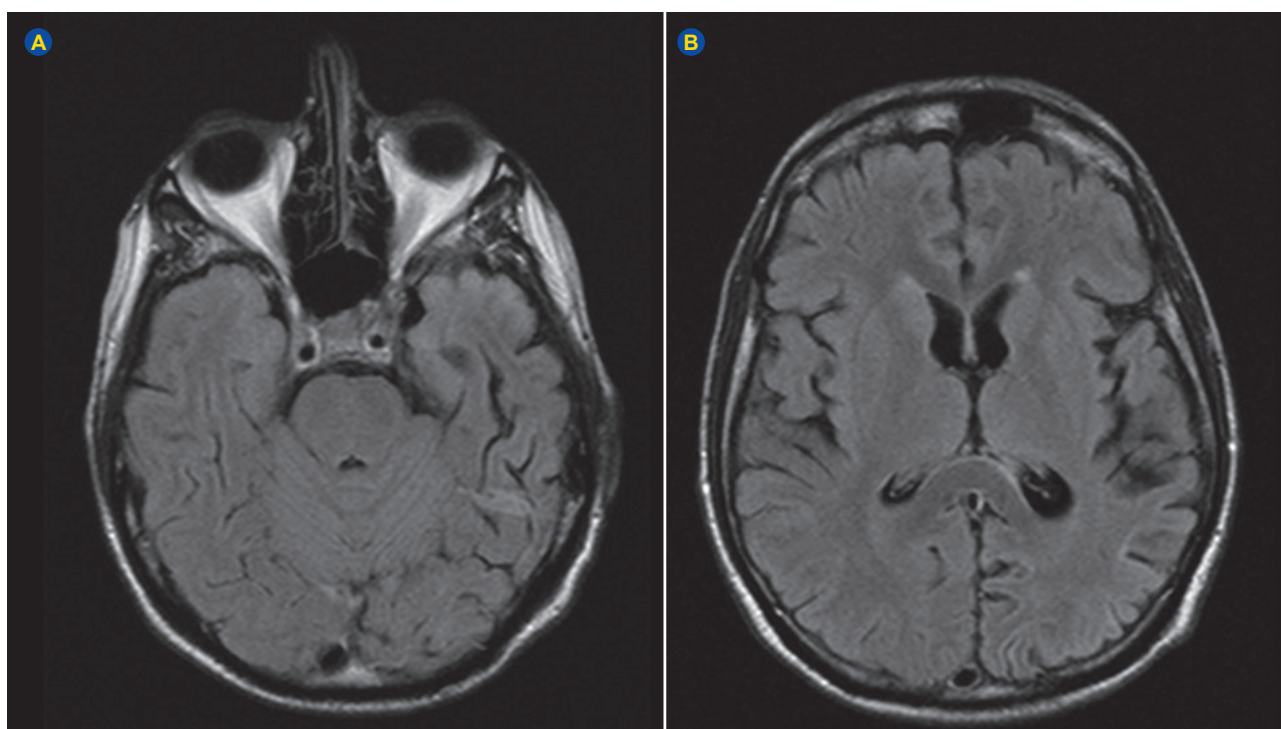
MRI in August 2019 showed reversal of imaging changes with increased peripheral cortical sulci, probably due to post encephalitis brain atrophy
